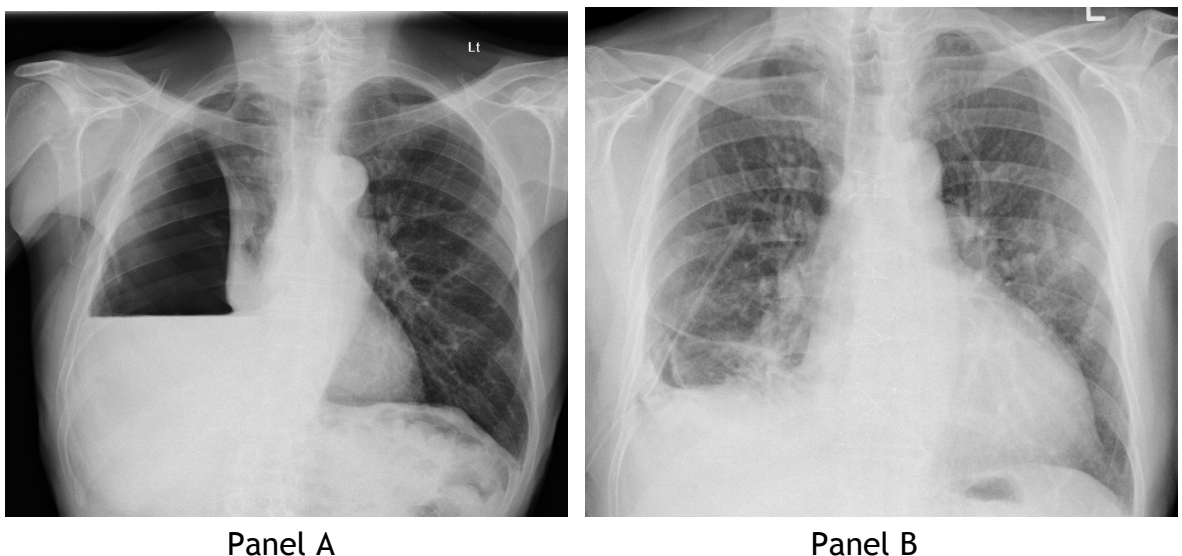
Chest radiographs showing varying degrees of NEL following drainage of MPE. Panel A shows no evidence of lateral or basal pleural re-apposition consistent with ‘complete NEL’. Panel B shows complete right upper lobe re-expansion but incomplete middle and lower lobe re-expansion consistent with a degree of partial NEL.
